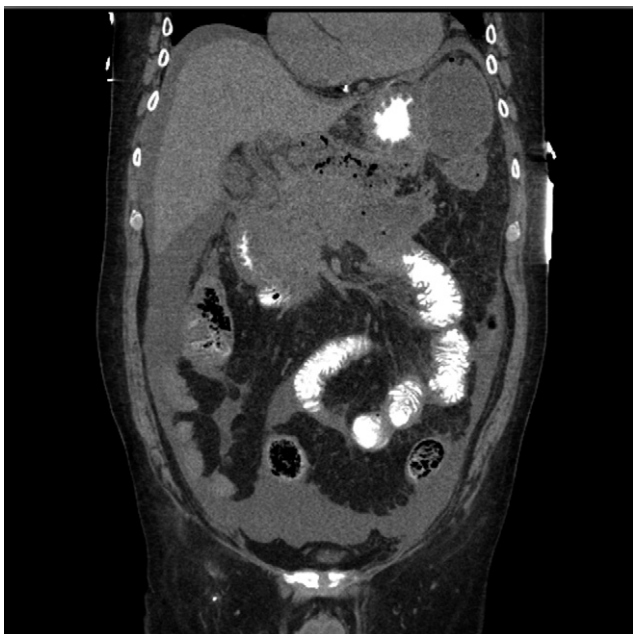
Infected necrosis. Computed tomography scan demonstrating infected necrosis. Note the presence of air bubbles in the necrotic collection.
